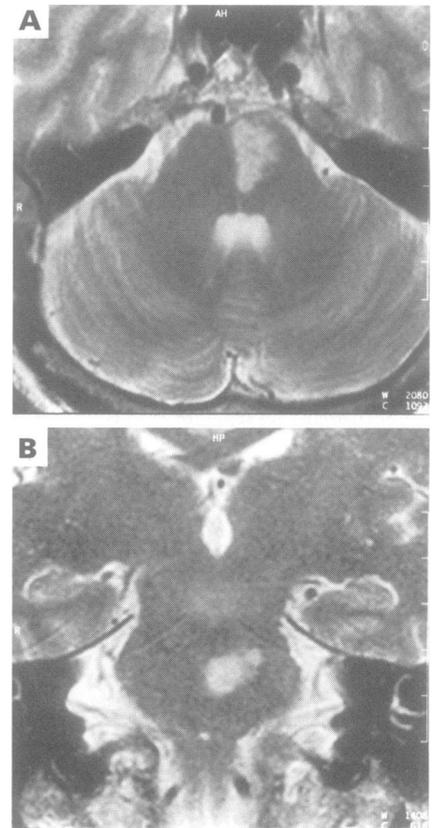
Detection of a single left paramedian midpontine ischaemic lesion by MRI (1.5 Tesla, fast spin echo sequence) four days after the onset of symptoms. (A) axial T2 weighted images (TR/TE 3000/85 ms); (B) coronal T2 weighted images (TR/TE 3000/85 ms).
